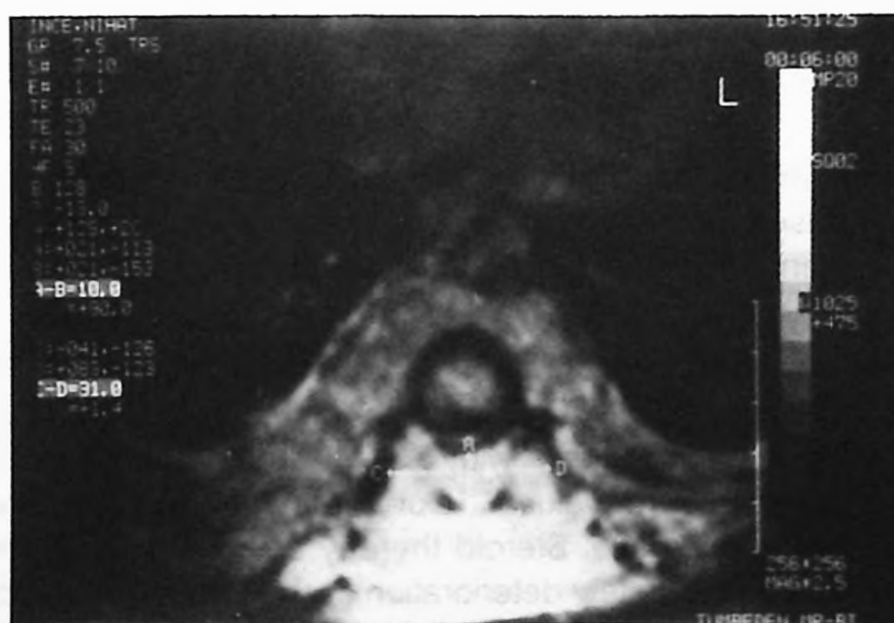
Magnetic resonance imaging of the spine demonstrating paraspinous mass.
